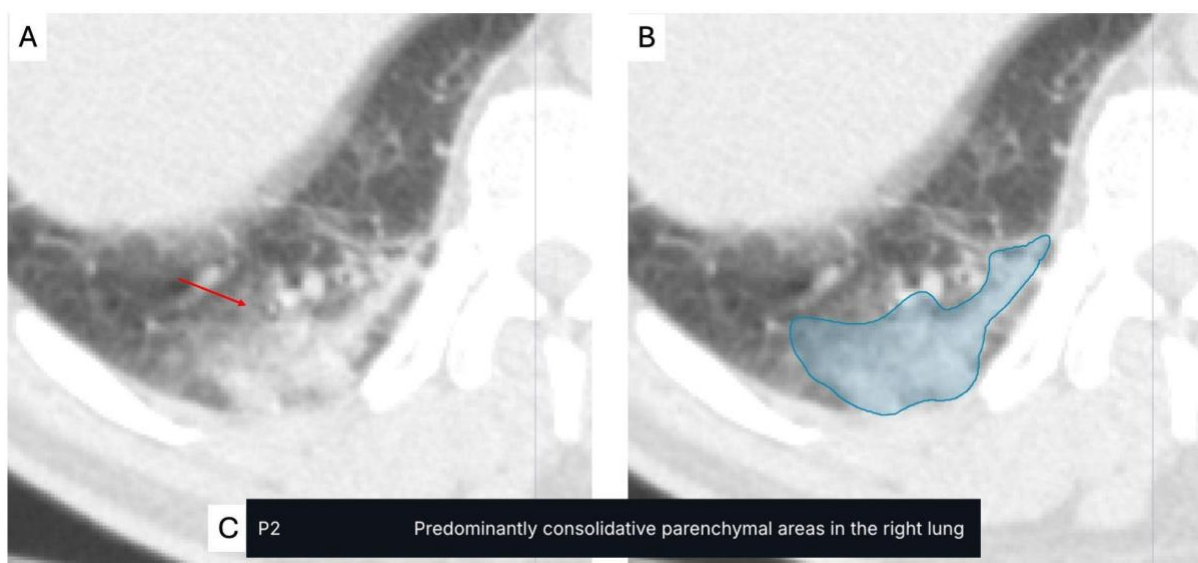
Axial view of CT Chest opened in the RedBrick AI annotation platform, showing areas of consolidation in the right lower lobe (A), segmented in the axial view using annotation tools (B), with corresponding free-text from interpreting radiologist (C).
